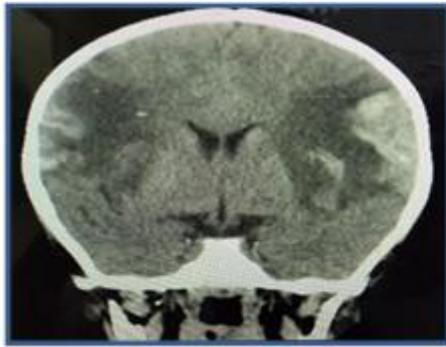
CT brain showed
